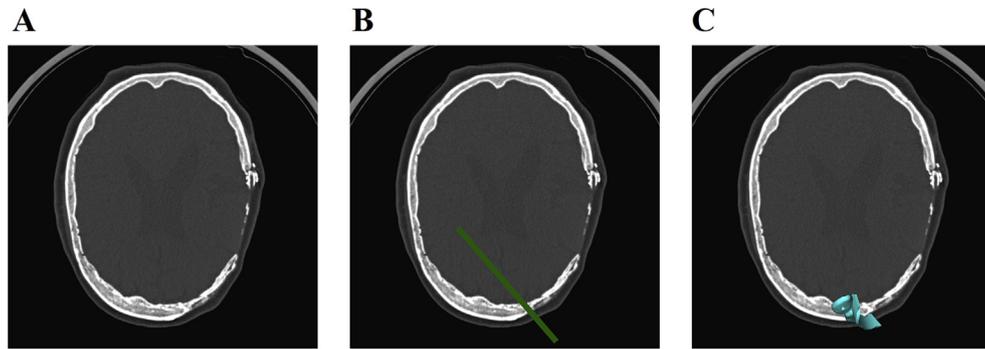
CT axial slice with (A) resorption of autologous bone, (B) resection outline, (C) planned resection template.
